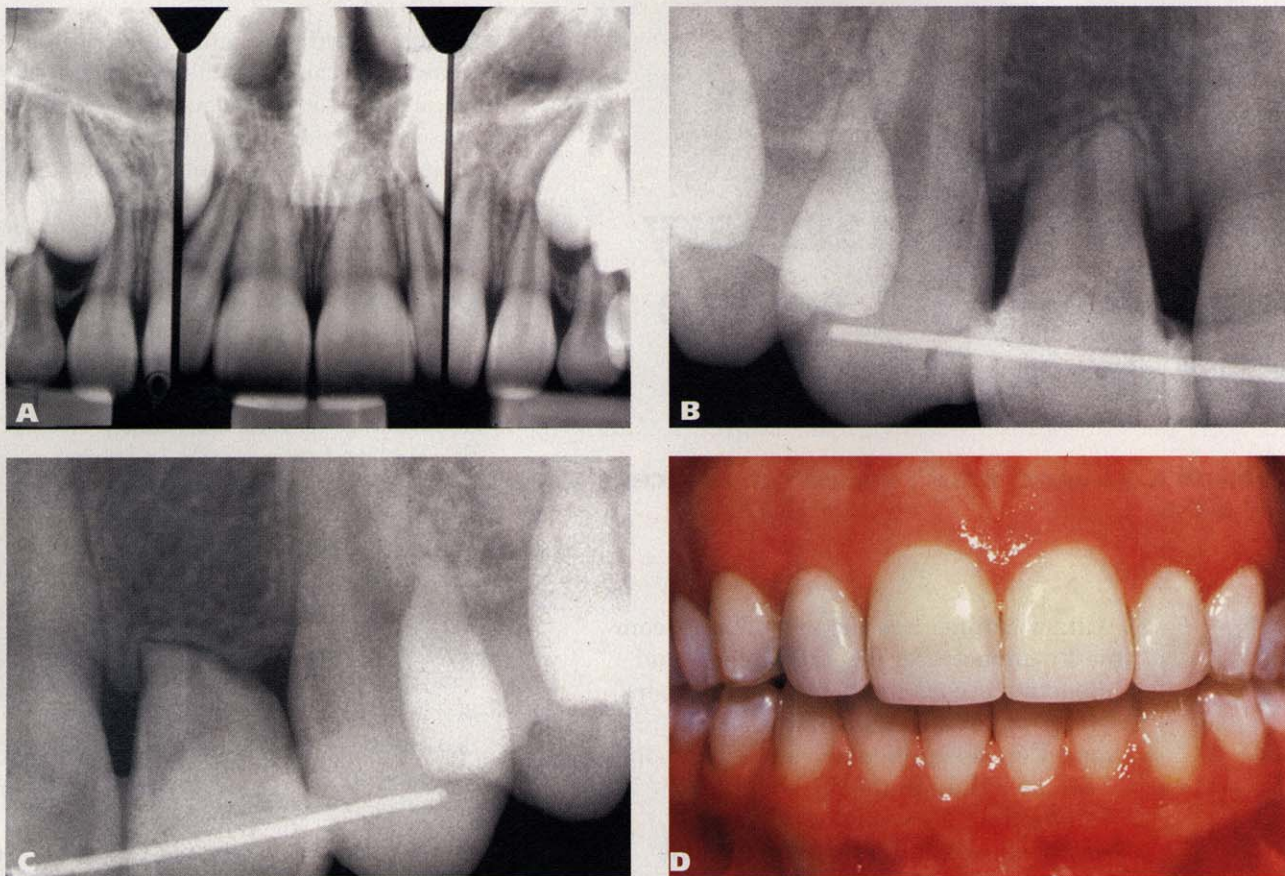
Periapical radiograph of the maxillary lateral incisors taken at the end of the first phase of treatment showed no root resorption (A). Radiographs of the lateral maxillary incisors five years after the orthodontic treatment, showed that the roots had not shortened any further (B,C). Photograph taken seven years after the second phase of orthodontic treatment showed that the lateral incisors still were in place and were not mobile (D).
